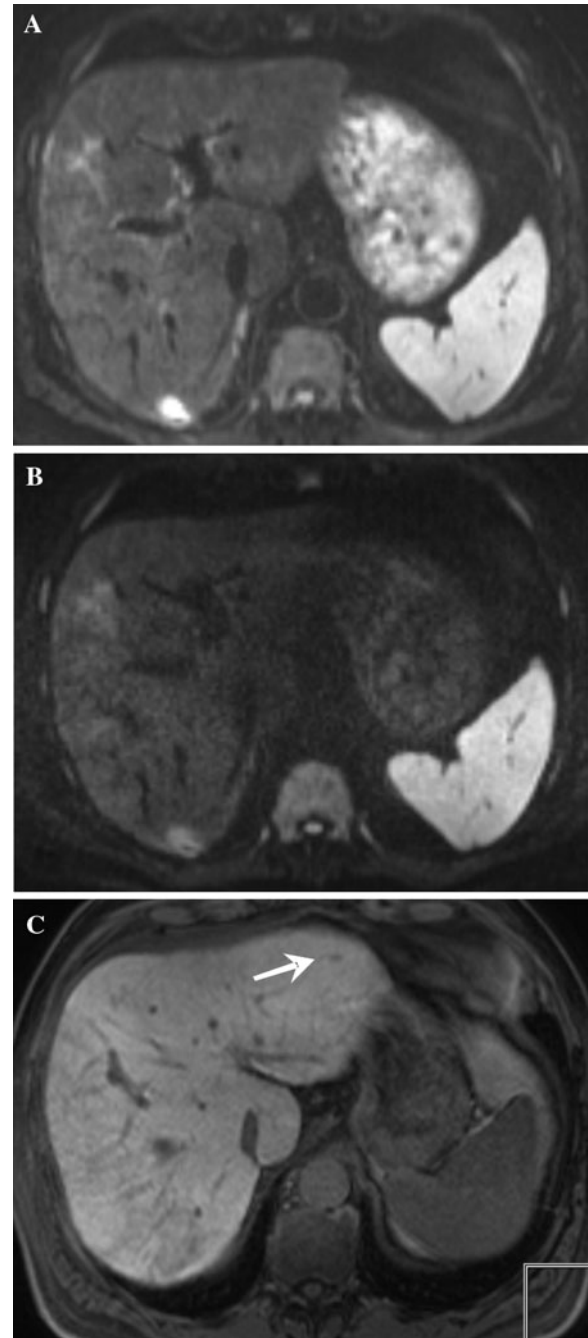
MR images of a 62-year-old man with colorectal cancer. In the left liver lobe no focal liver lesion is seen at $b = 50 \text{ s/mm}^2$ (A) and $b = 600 \text{ s/mm}^2$ (B) in DWI. However, although subtle, gadoteric acid-enhanced MR imaging (C) (20 min post injection) reveals a small hypointense lesion (*arrow*). In follow-up imaging considerable growth confirmed a metastasis
